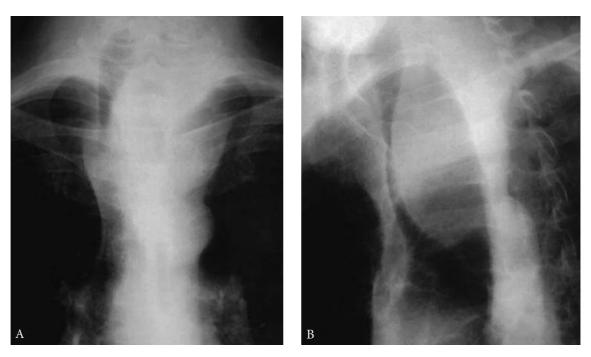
Intrathoracic (substernal) goiter in a 72-year-old man with a history of dyspnea, dysphagia, and stridor for several years. Chest roentgenograms. A, Posteroanterior view showing marked displacement of the larynx and trachea to the right, with marked tracheal compression. B, Oblique view emphasizes severe tracheal deviation and compression, which reduced the airway cross section by over 80%. Complete relief followed removal of the bilateral adenomatous goiter by right total and left subtotal thyroidectomy via a collar incision and upper partial sternotomy.
